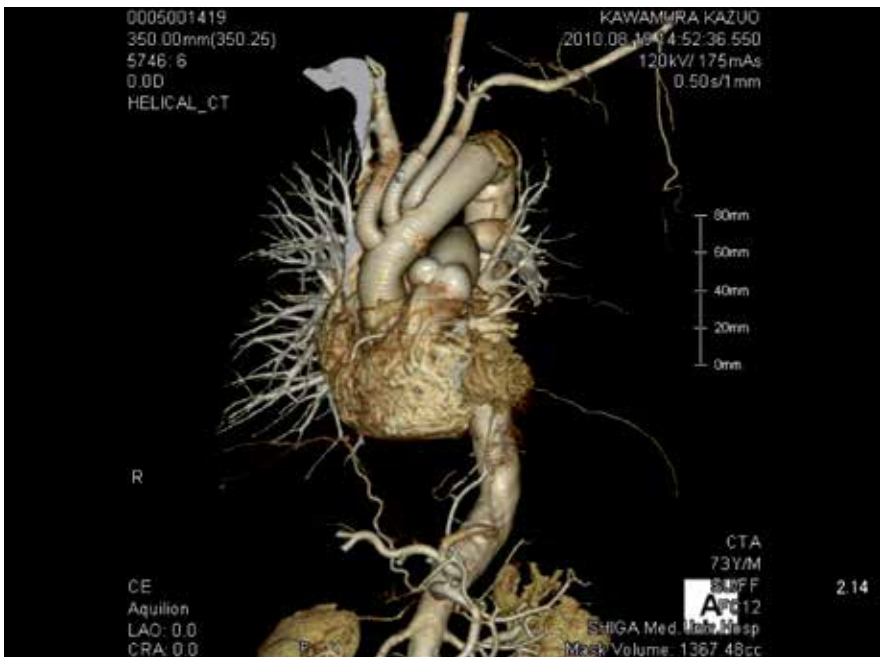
CT finding of repaired arch with a sealed quadrifurcated Dacron graft
